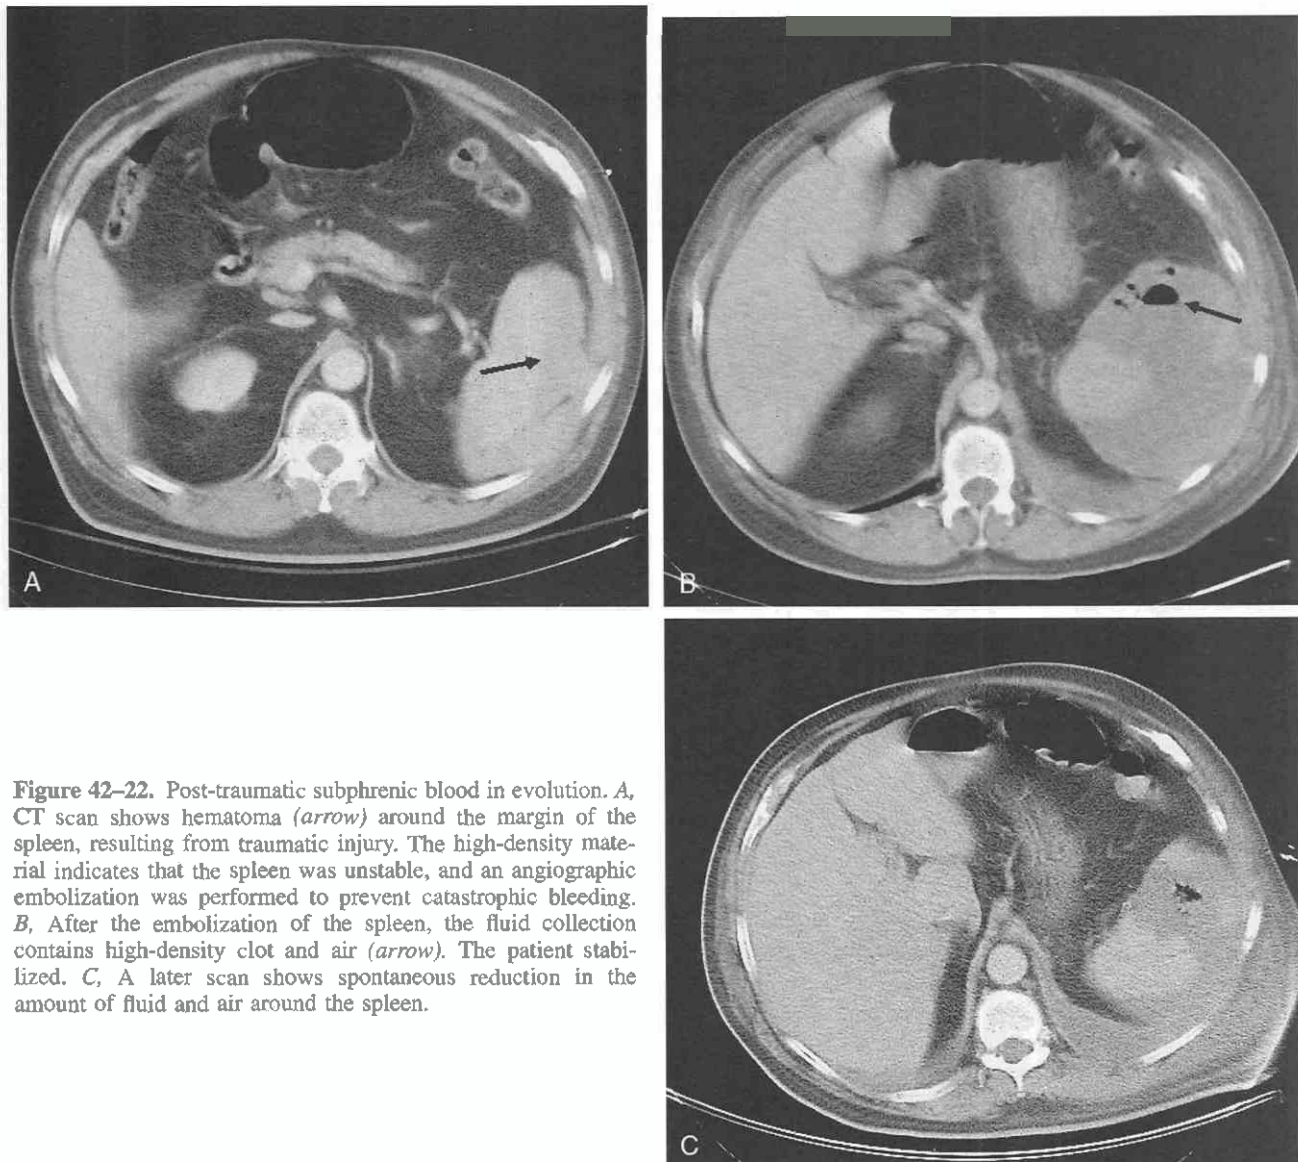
Post-traumatic subphrenic blood in evolution. *A*, CT scan shows hematoma (arrow) around the margin of the spleen, resulting from traumatic injury. The high-density material indicates that the spleen was unstable, and an angiographic embolization was performed to prevent catastrophic bleeding. *B*, After the embolization of the spleen, the fluid collection contains high-density clot and air (arrow). The patient stabilized. *C*, A later scan shows spontaneous reduction in the amount of fluid and air around the spleen.
